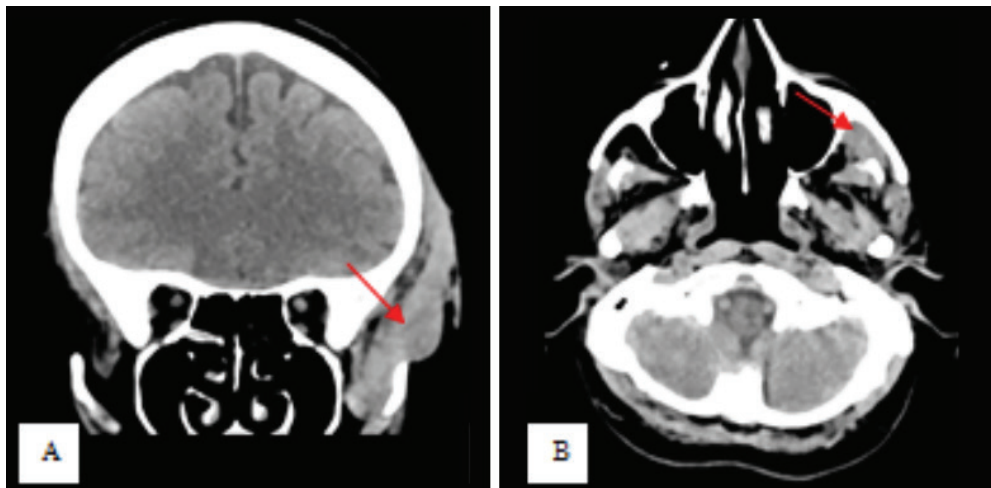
CT of the head showing the isodense left temporal region mass on coronal image (A, arrow). On axial images (A, B), the inferior extension of the mass obliterating the retroantral (buccal) fat at the left infratemporal fossa is seen (B, arrow). Small intraorbital part of the mass is shown (C, arrow)
